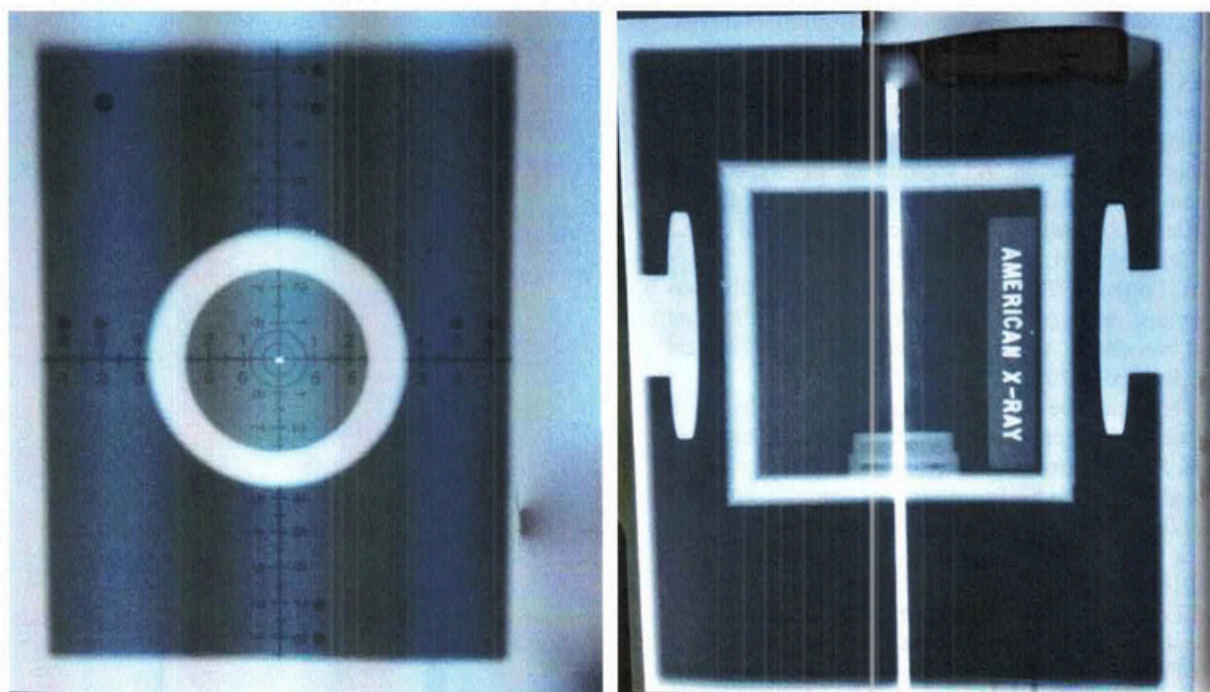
American X-Ray Corporation certifies precision tube to bucky alignment by testing points a certain distance from the central ray. Any small variation in alignment would produce a larger discrepancy due to divergent rays.
